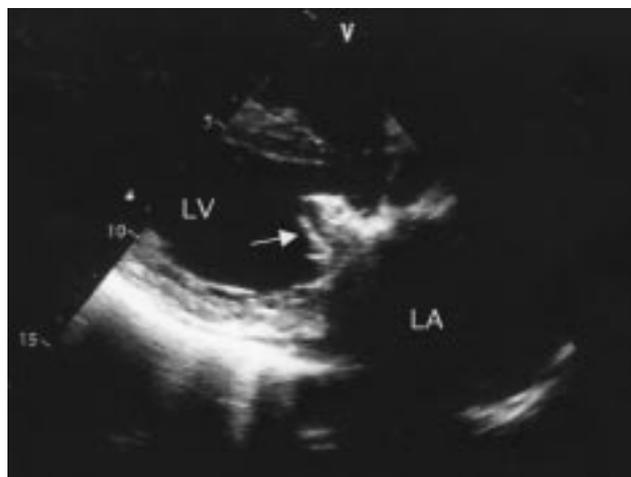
Preoperative transthoracic echocardiogram patient 4. LV, left ventricle; LA, left atrium. Arrow: cloth wear.
